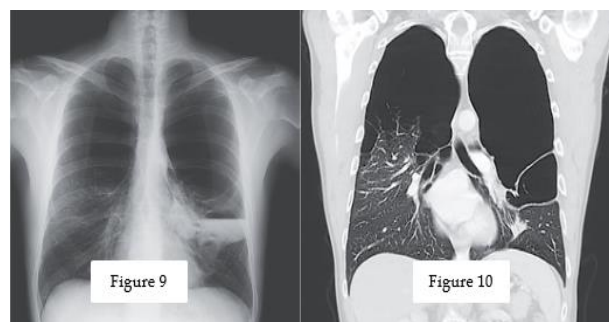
CXR and Chest CT coronal Giant Bollous image in normal lung (Type 1)
